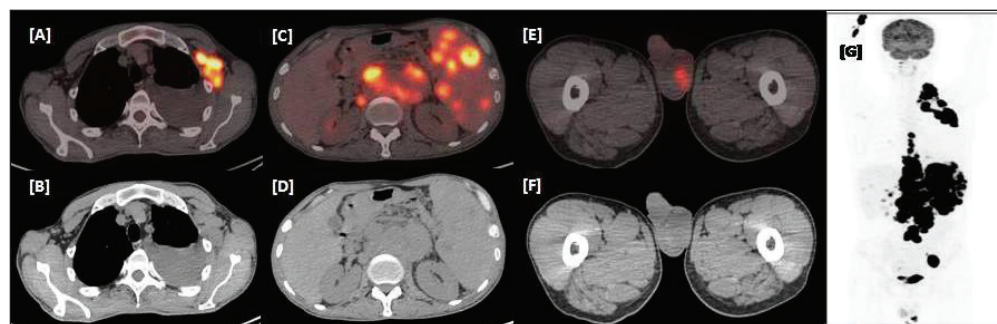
(a-d) ¹⁸F-FDG PET/CT revealed multiple hypermetabolic lymph nodes involving both sides of diaphragm with multiple hypermetabolic hypodense lesions involving spleen. (e, f) Along with that heterogenous FDG uptake and calcification noted in enlarged left testis.
